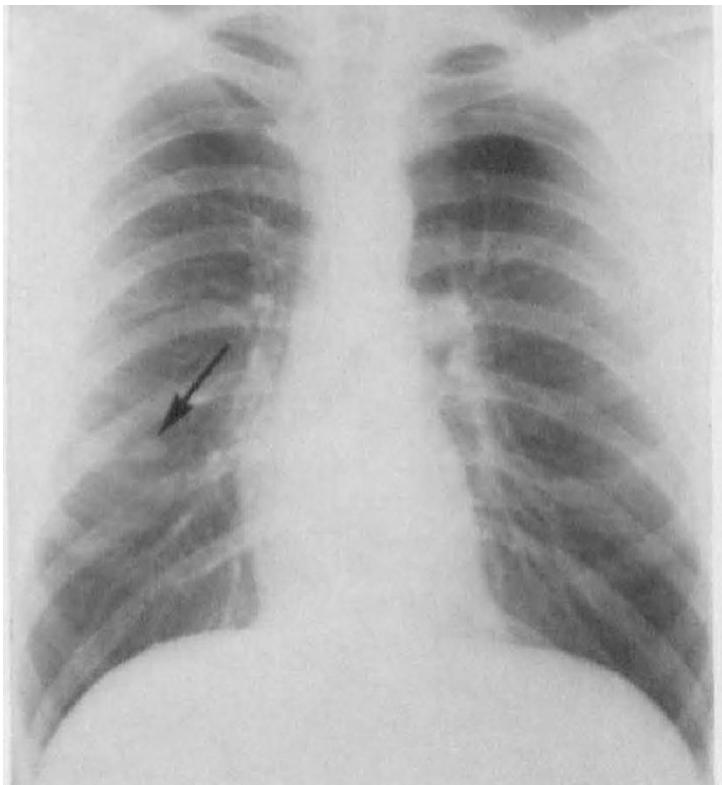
Roentgenogram of the chest showing a density in the superior segment of the right lower lobe of the lung.
